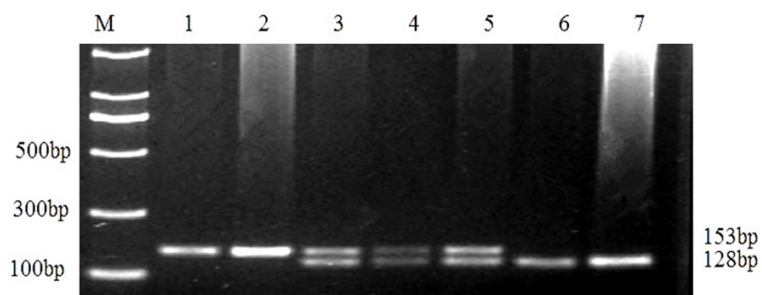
Agarose gel electrophoresis images for *TCF7L2* rs290487. 1 and 2 lanes: TT genotype; 3-5 lane: CT genotype; 6 and 7 lanes: CC genotype.
